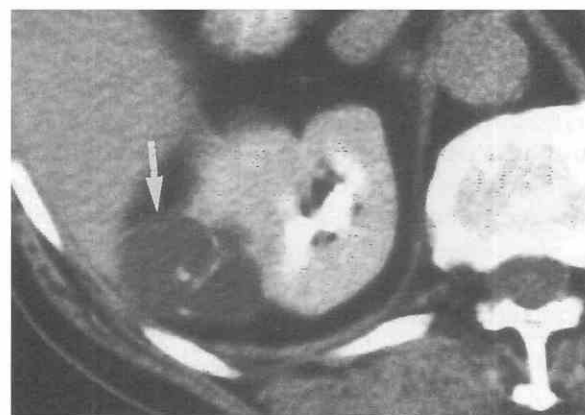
Minimally calcified benign cyst (arrow); category II lesion. A contrast-enhanced CT scan reveals fine linear calcification in the cyst wall and septa. The lesion shows a thin wall, and no focal nodules or areas of enhancement. The fluid in the cyst measured 12 HU.
